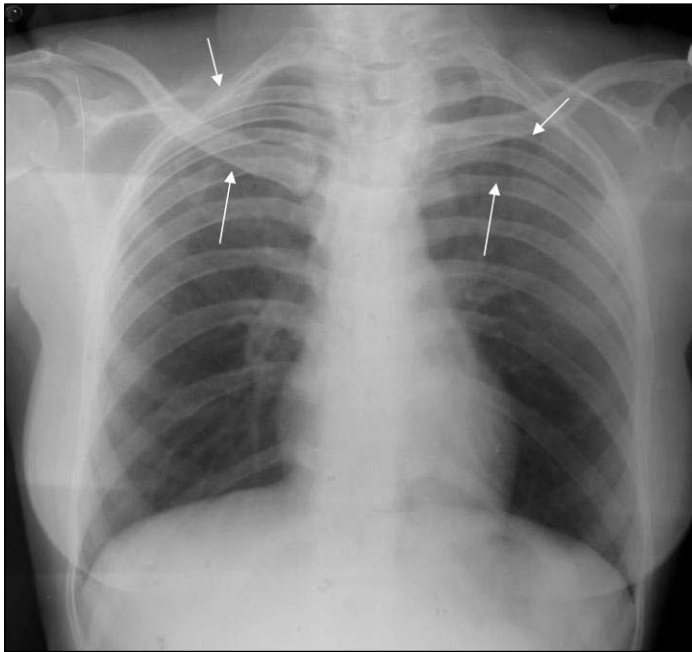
Chest X-ray showing crowding of ribs (arrows).
